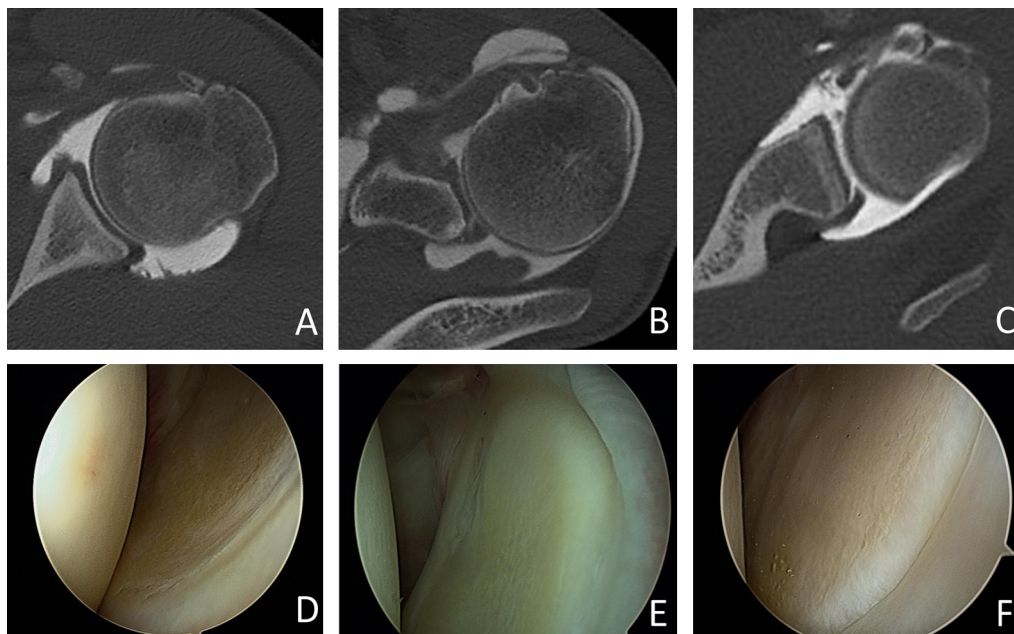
Arthro-CT of a directly inserted posterior labrum (A), a medialized posterior superior labrum (B) (not considered a pathologic aspect of a posterior Bankart lesion) and a medialized posterior medial labrum (C). Arthroscopic aspect of a directly inserted inferior segment of the posterior labrum (D), a posterior labrum with medialized superior and medial segment (E) (type 3) and a directly inserted medial segment (F).
